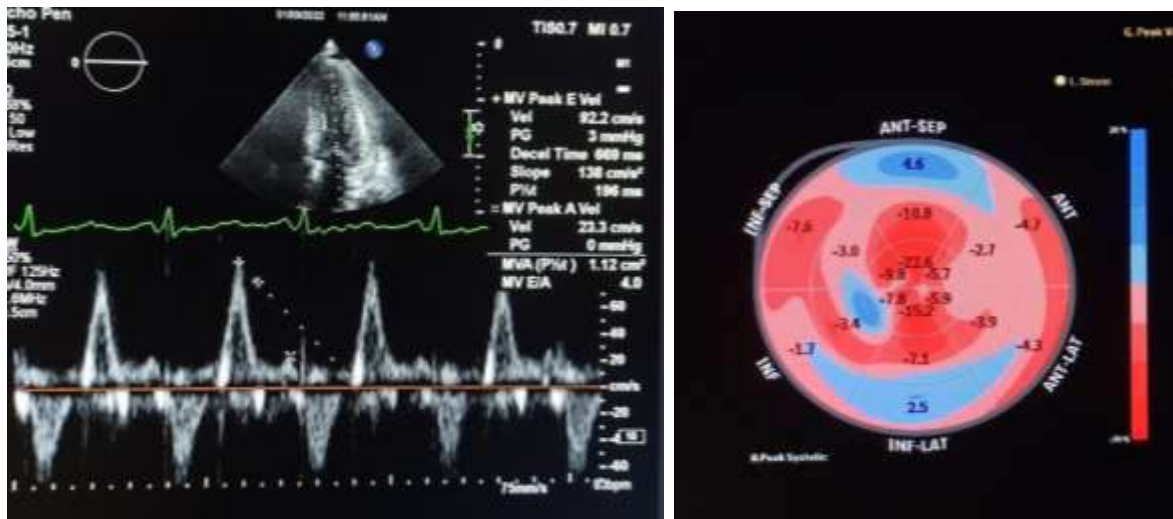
2D Echocardiogram & Global Left Ventricular Strain
